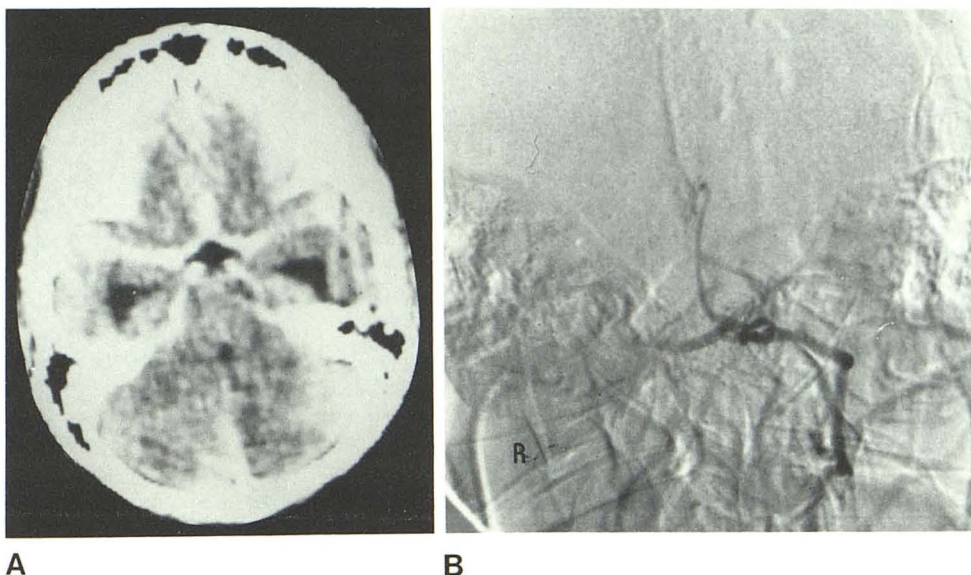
Case 2. Contrast CT. Isodense posterior fossa structures, displacement of small fourth ventricle to left and anteriorly, dilatation of both temporal horns, obliteration of posterior fossa cisterns, and nonopacification of basilar artery. Low densities within brainstem (B) were believed to be artifactual.
